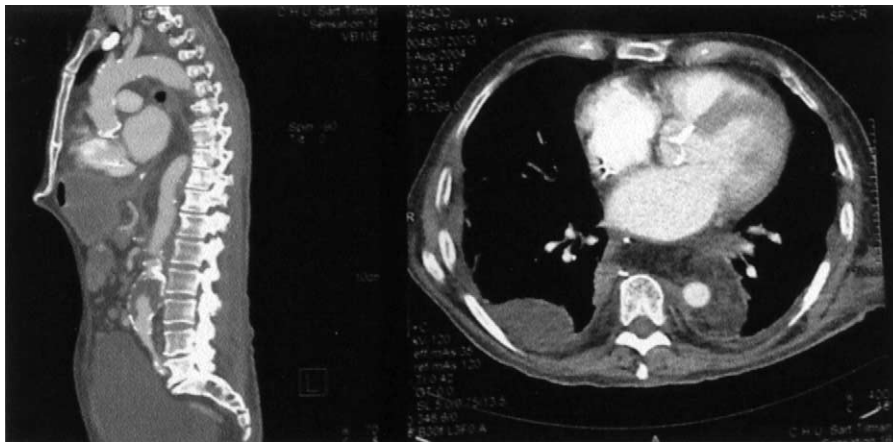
Postoperative magnetic resonance image of the thoracic allograft and omentoplasty around the allograft.
